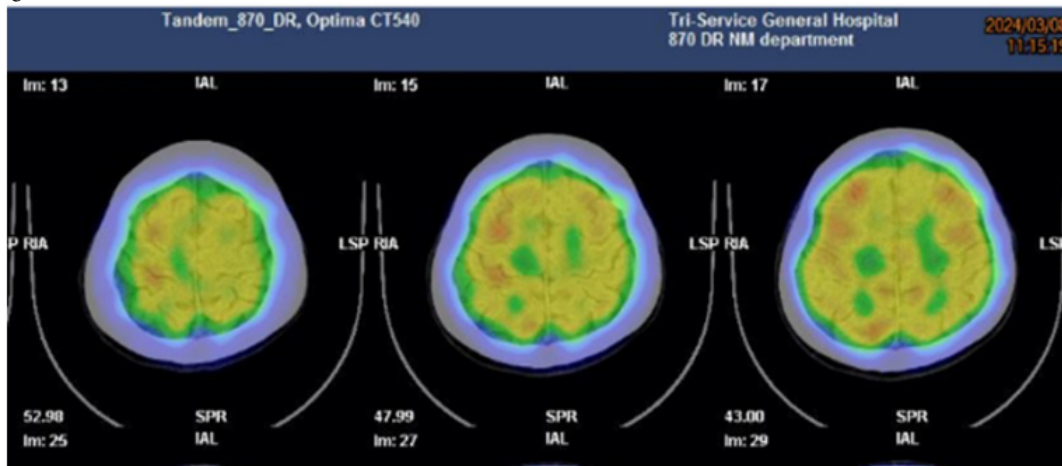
The SPECT-CT shows the continuous transverse view from head to feet, finding inhomogeneous uptake of the cerebral cortex with mildly decreased uptake over the left frontal and parietal lobes.
